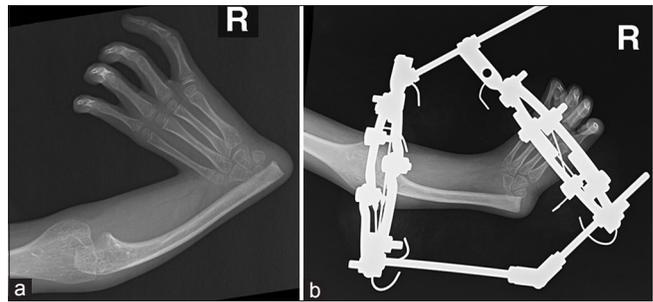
Plain radiographs of the right forearm and the hand showing (a) the preoperative radial club hand deformity (hand-forearm angle: +76°) and (b) immediate postoperative radiographs following application of Ilizarov fixator
